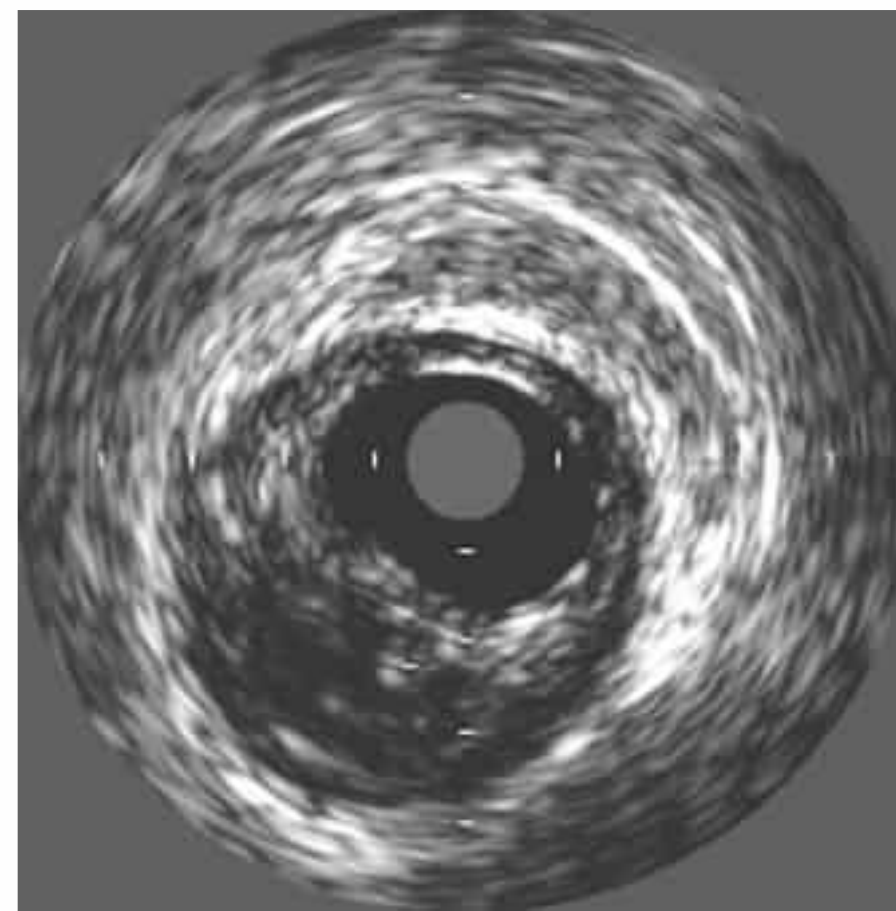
Intravascular ultrasound image of complicated plaque formation (Stary type Va) with high-grade narrowing of the perfused lumen.
